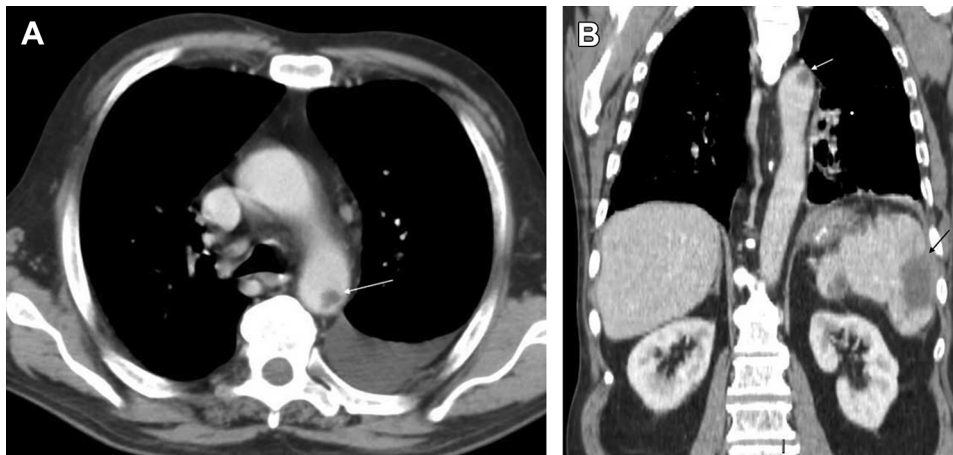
Figure Axial and coronal contrast enhanced computed tomography scan showing (A) a floating thrombus in the proximal descending aorta (white arrow) and (B) a hypodense splenic lesion consistent with infarction (black arrow). No atherosclerotic changes are seen in the aorta.
